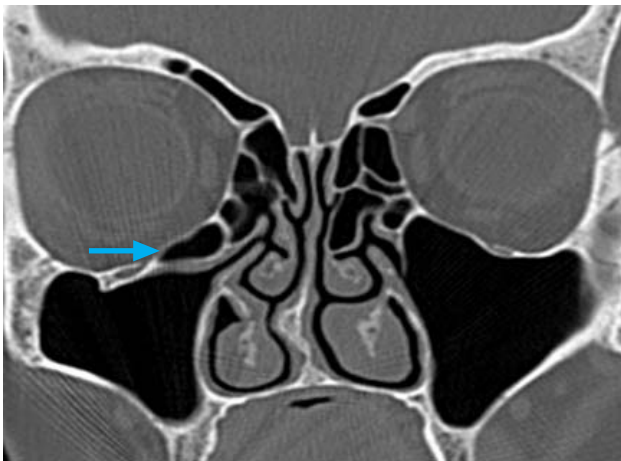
Coronal view CT scan PNS showing Haller cells (pneumatized infraorbital anterior ethmoid cells found between the maxillary sinus and the orbit on right side).
